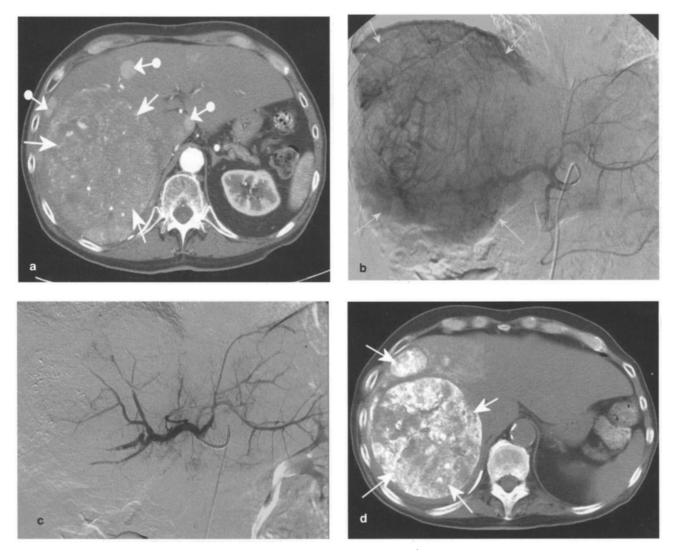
a-d: Huge multifocal HCC with neoangiosis and A-V shunts. Selective catheterization and embolization. Postoperative CT scan.
